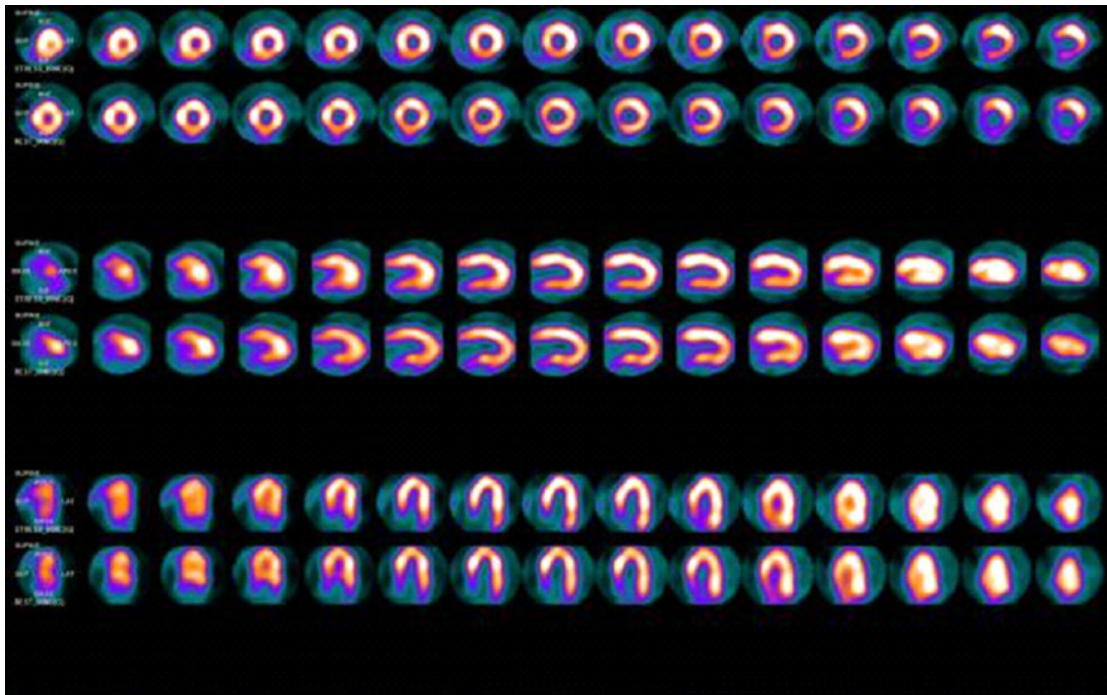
Case 4 - Myocardial perfusion scintigraphy within normality. Images acquired with dedicated cardiac equipment, equipped with solid cadmium-zinc-tellurium detectors.
